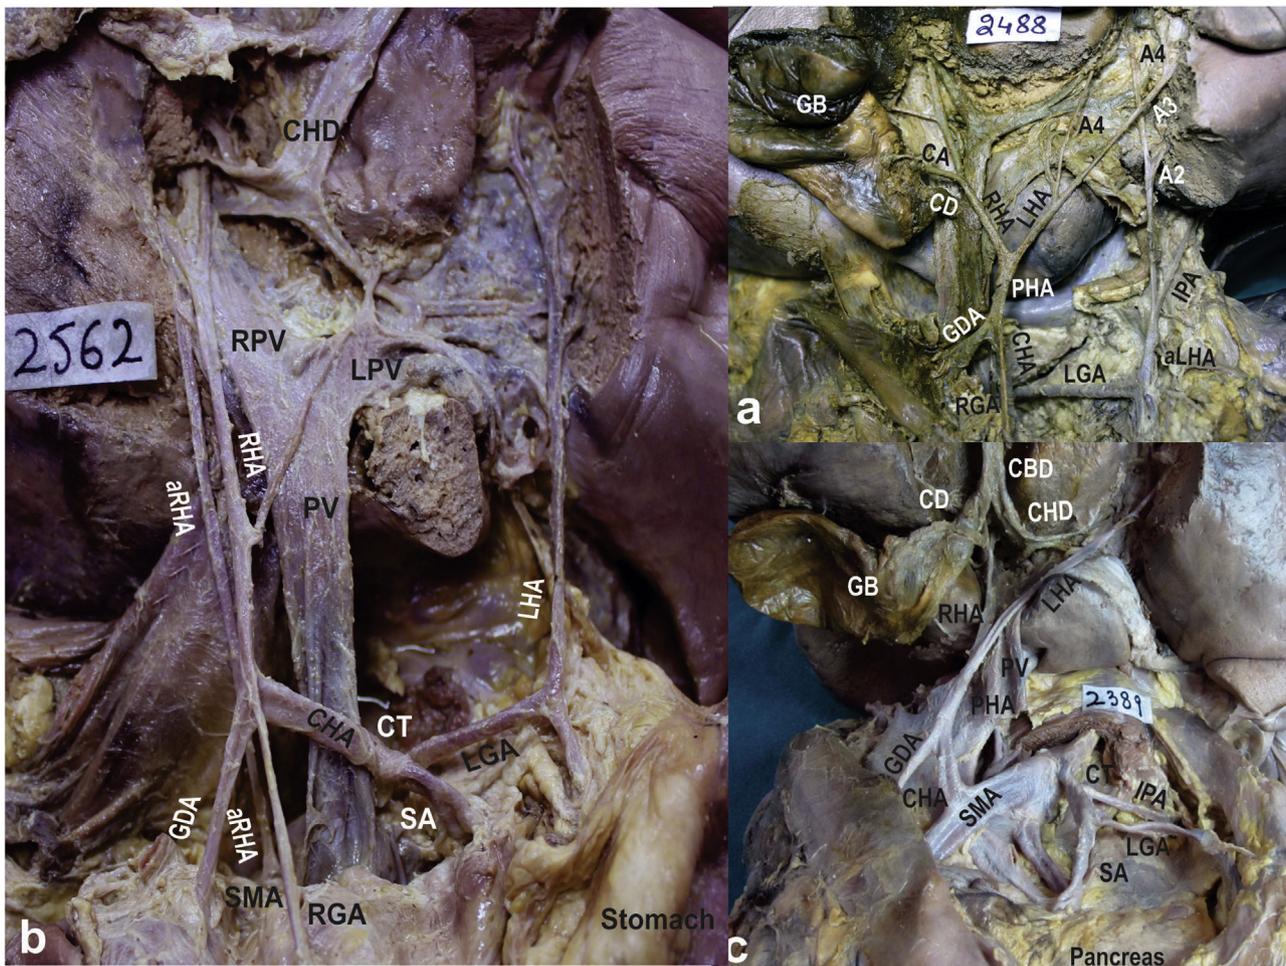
Anterior view of the hepatic pedicle showing origin of HAs a. Accessory LHA is arising from LGA in addition to normal LHA from PHA. b. Replaced LHA is originating from the LGA and accessory RHA from the SMA. CHA originating from CT is continuing as RHA. c. Replaced CHA is originating from the SMA.
